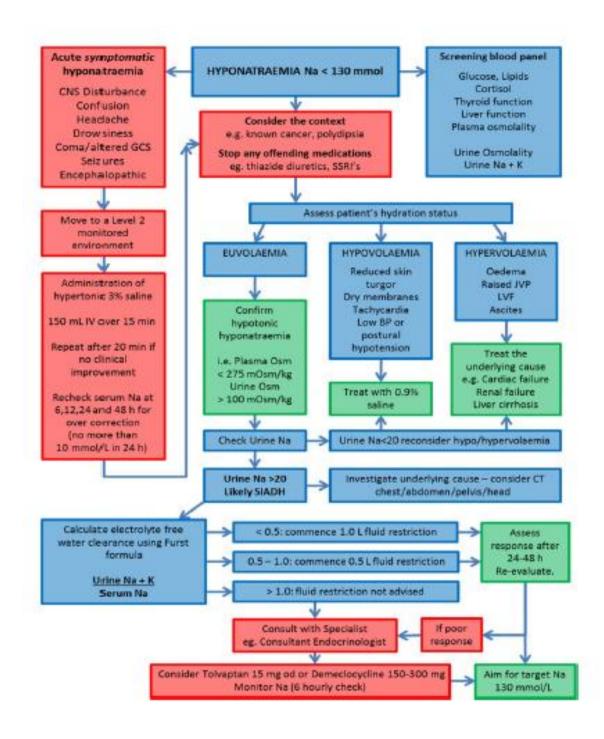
Algorithm for management of inpatients with hyponatraemia. CNS, central nervous system; CT, computed tomography; GCS, Glasgow Coma Score; IV, intravenous; JVP, jugular venous pressure; K, potassium; LVF, left ventricular fibrillation; Na, sodium; od, once daily; Osm, osmolality; SSRI, selective serotonin reuptake inhibitor
